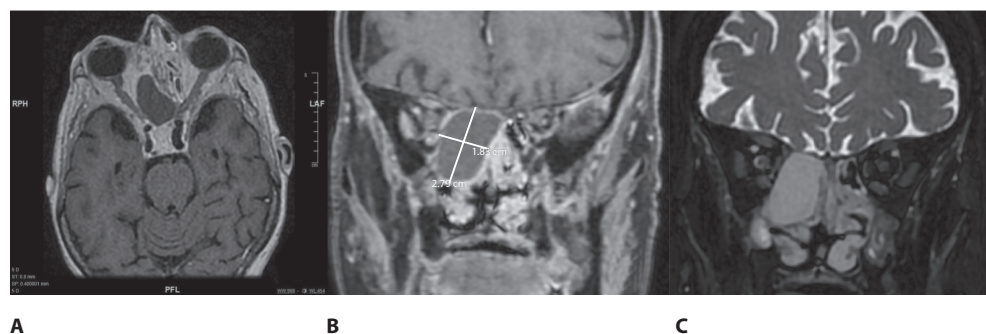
MRI Showing oval-shaped mass lesion centered within the right ethmoid air cells extending posteriorly to the sphenoid sinus. The lesion exhibits low T1 signal intensity with no enhancement in post-contrast images (A, B). High T2 and flair signal (C)
